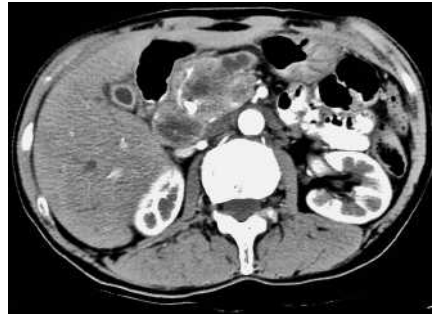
Computed tomographic scan showing an irregularly enhancing mass at the head of the pancreas.
